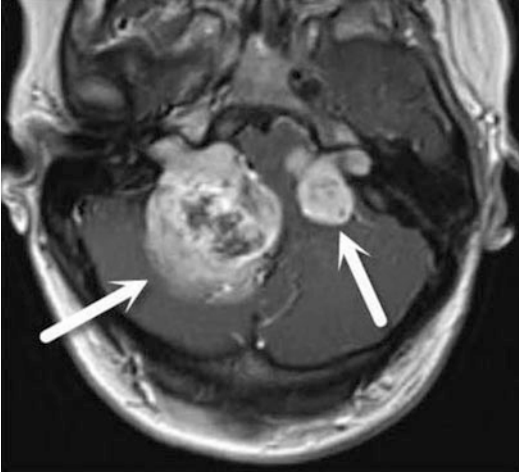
Post contrast MRI image of brain on a 16-year-old female presenting with hearing loss demonstrates avidly enhancing extra-axial masses bilaterally in the posterior fossa (*arrows*). These masses are herniating into and causing expansion of the internal auditory canal without any bony destruction consistent with bilateral acoustic schwannomas. Mass effect on the brainstem and cerebellum is also identified (Courtesy of Dr. Grace Guo and Dr. Arabinda Choudhary)
